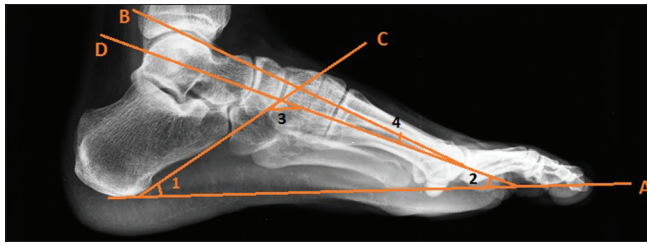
Radiographic picture showing four lines and angles
